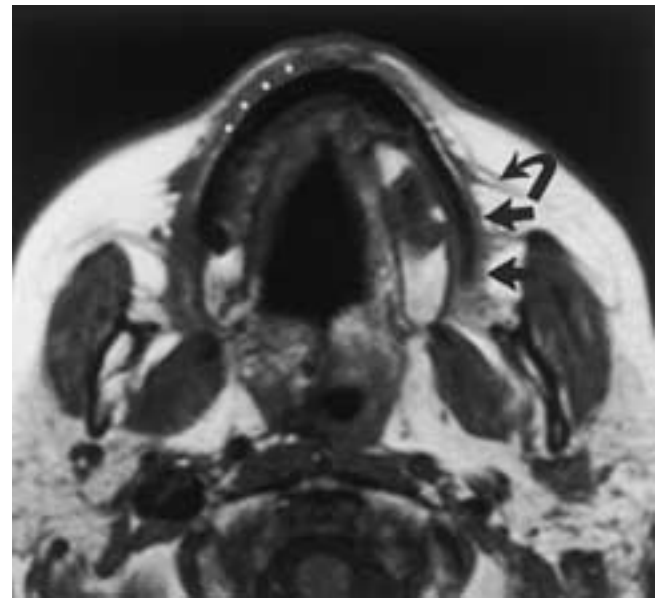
Early chronic facial nerve denervation in a woman who had undergone left parotid gland surgery. Axial T1-weighted MR image reveals fatty replacement and volume loss involving the left buccinator (*straight arrows*) and zygomaticus (*curved arrow*) muscles. Also note the involvement of other small mimetic facial muscles on the left compared to the normal muscle mass on the right (*dots*).
